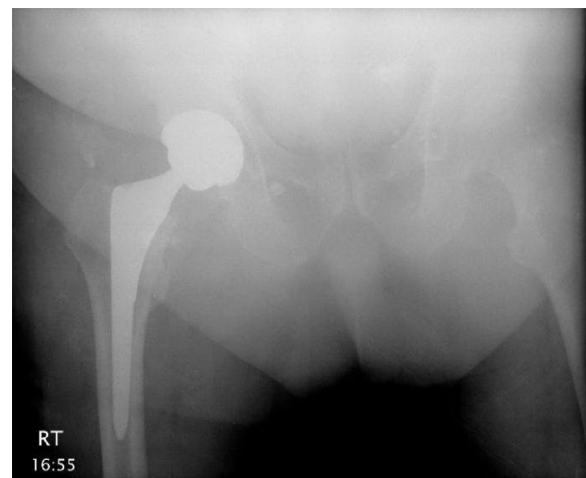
Postoperative anteroposterior pelvis radiograph from September 2008 after right total hip arthroplasty.
